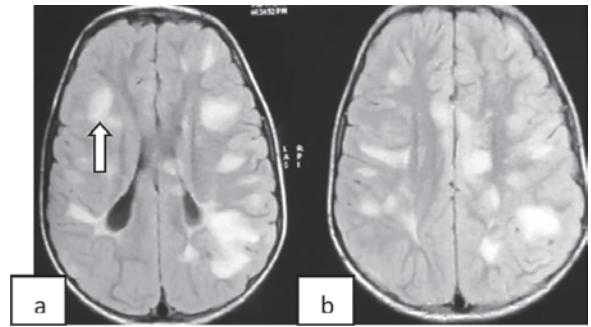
a & b. Acute disseminated encephalomyelitis Axial MR FLAIR sequences show bilateral, asymmetric, multiple hyperintense lesions in the deep and subcortical white matter
